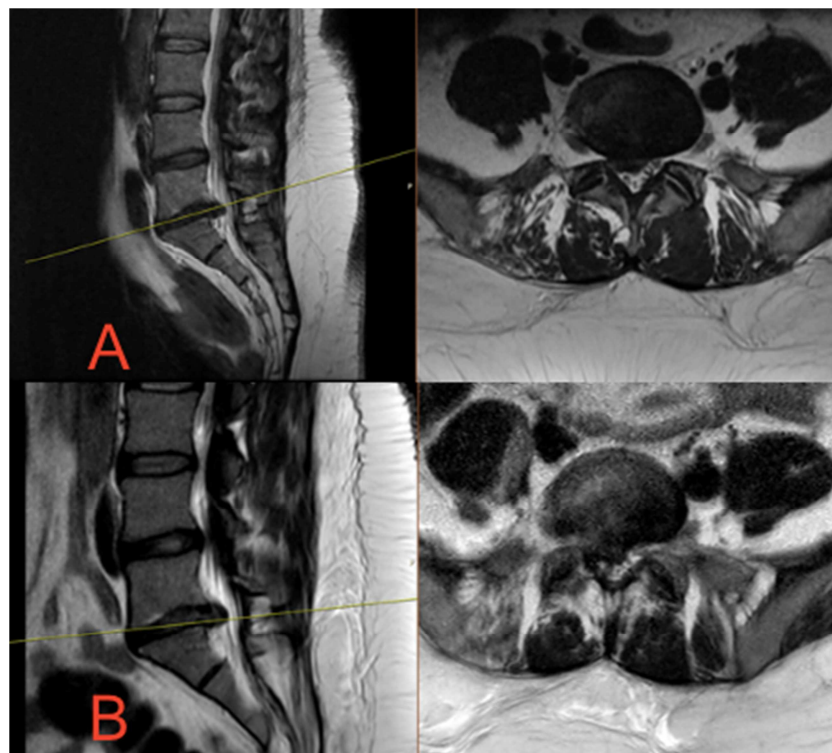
The preoperative (A) and postoperative (B) magnetic resonance imaging showed uncompressed nerve root.
